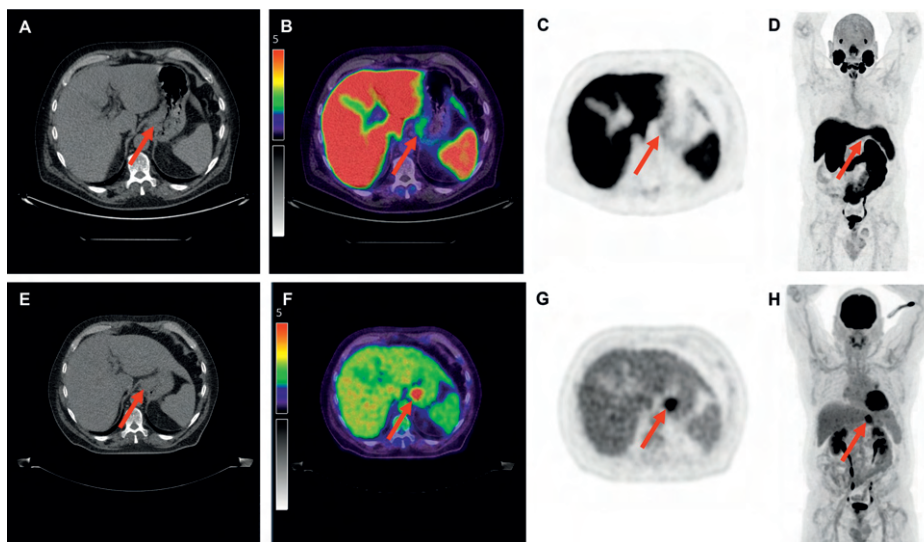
Overview of imaging modalities of a patient with cT4N1M0 tubular gastric carcinoma (patient 6). The arrows indicate (upper row) a lesion with light $[^{18}\text{F}]\text{DCFPyL}$ expression with an SUV_{max} of 2.5 and (bottom row) a lesion with $[^{18}\text{F}]\text{FDG}$ uptake with an SUV_{max} of 7.8. From left to right: low-dose CT (A,E), fused PET/CT (B,F), PET (C,G), and the maximal intensity projection (MIP, (D,H)). Image scale SUV 0-5.
